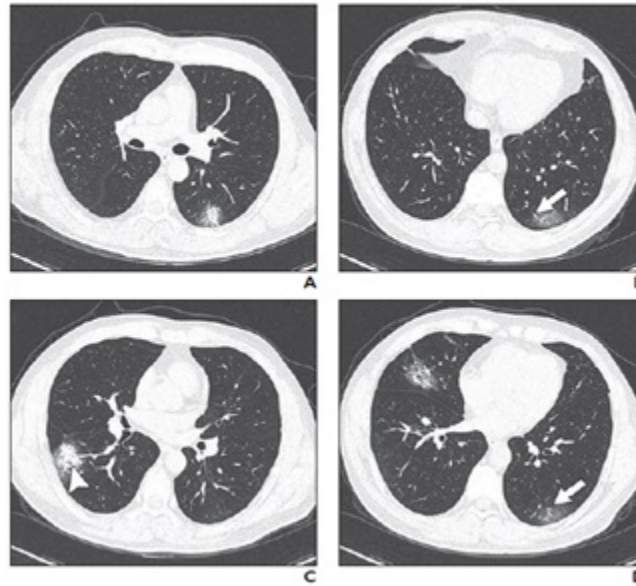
A 37-year-old male patient presents with complaints of 38C fever and cough after a brief history of being in Wuhan. Bilateral multifocal GGO, bronchiectasis (C) and vascular enlargements (B, D) are seen on CT scans elicited on admission.
